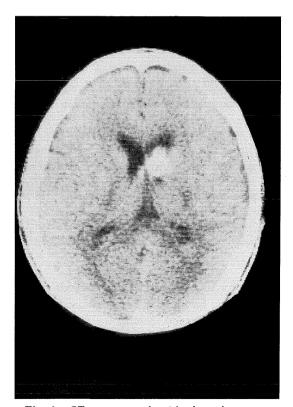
CT scans on the 8th day after onset (plain CT).
